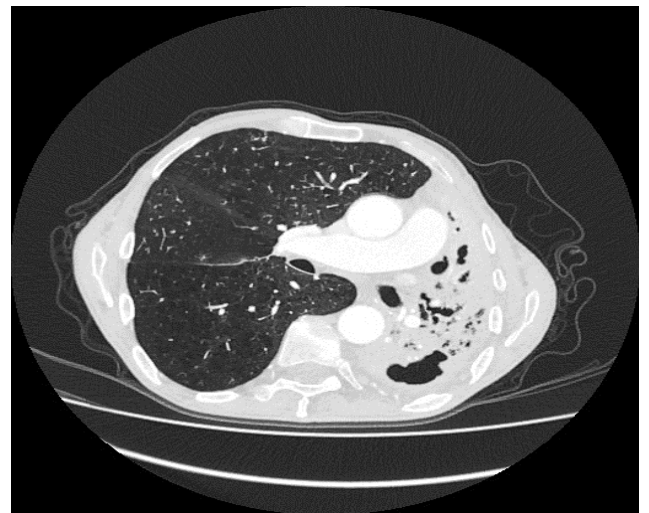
Patient I (chest CT scan).
